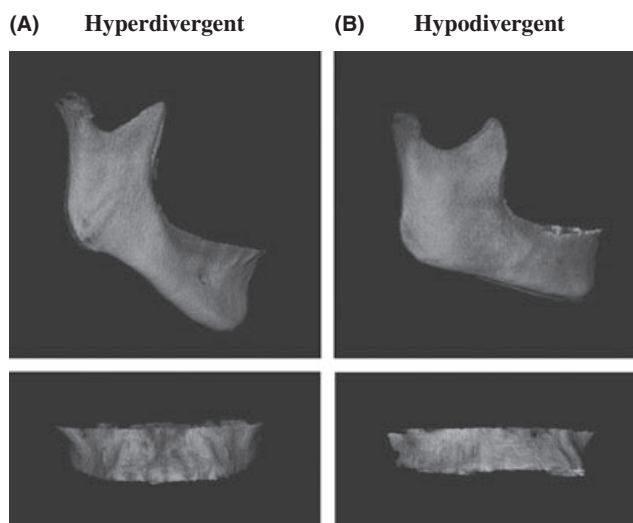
Cone beam 3D image of maxilla and mandible without crown of teeth. (A) Hyperdivergent subject. (B) Hypodivergent subject.
